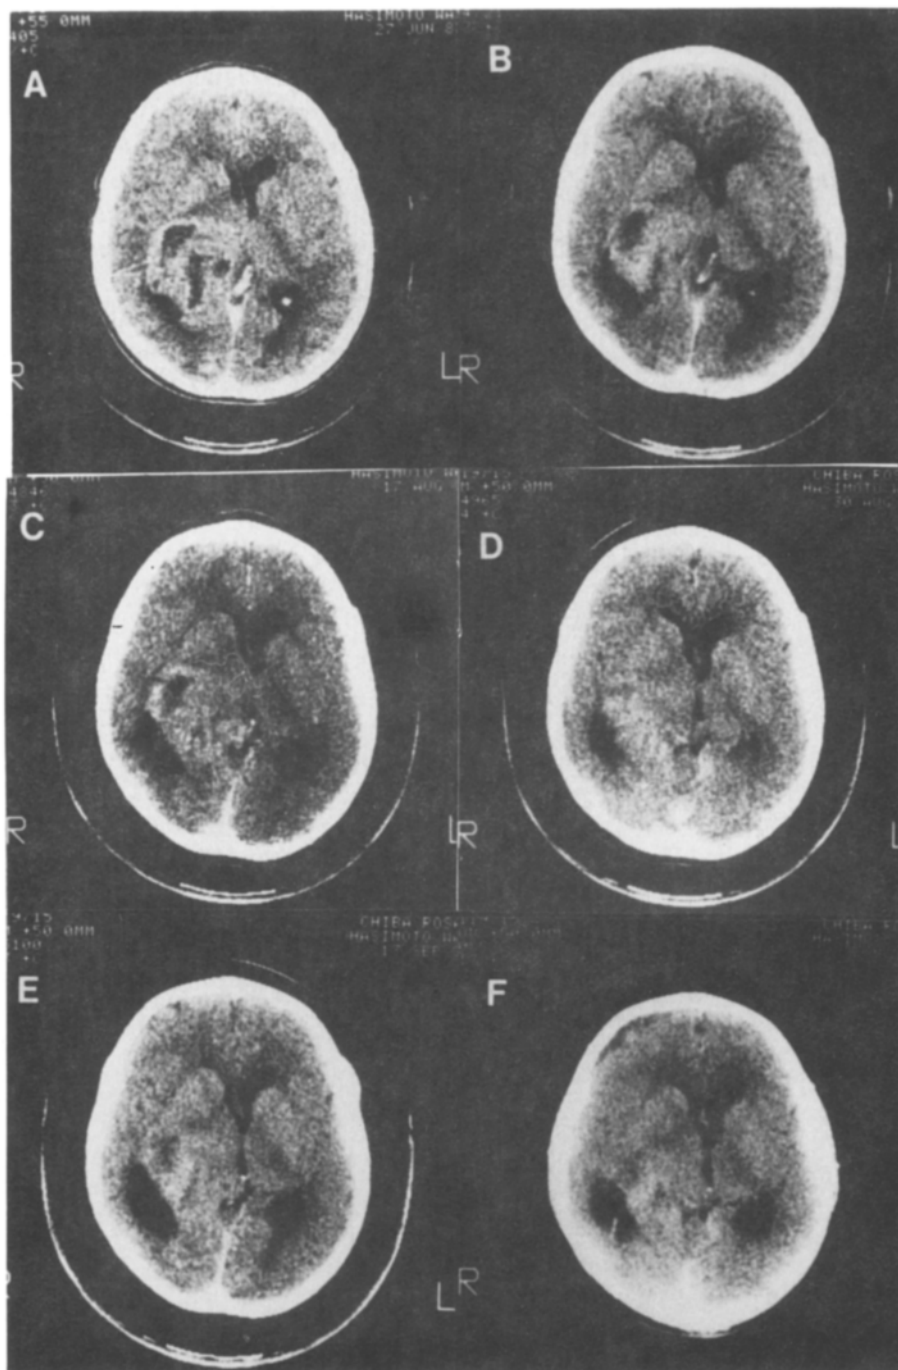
Regression of the right thalamic glioblastoma multiforme of case 2 was revealed by serial contrast-enhanced CT scanings. Film A was taken 2 weeks before the first injection of the autologous T cell line, B was taken just after the 3rd injection (at 3 weeks after the initiation of the therapy), C: after the 7th injection (at 5 weeks), D: after the 9th injection (at 7 weeks), E: after the 11th injection (at 9 weeks), and F was taken after 5 weeks after the final (13th) injection, that was 16 weeks after the first injection, respectively.
